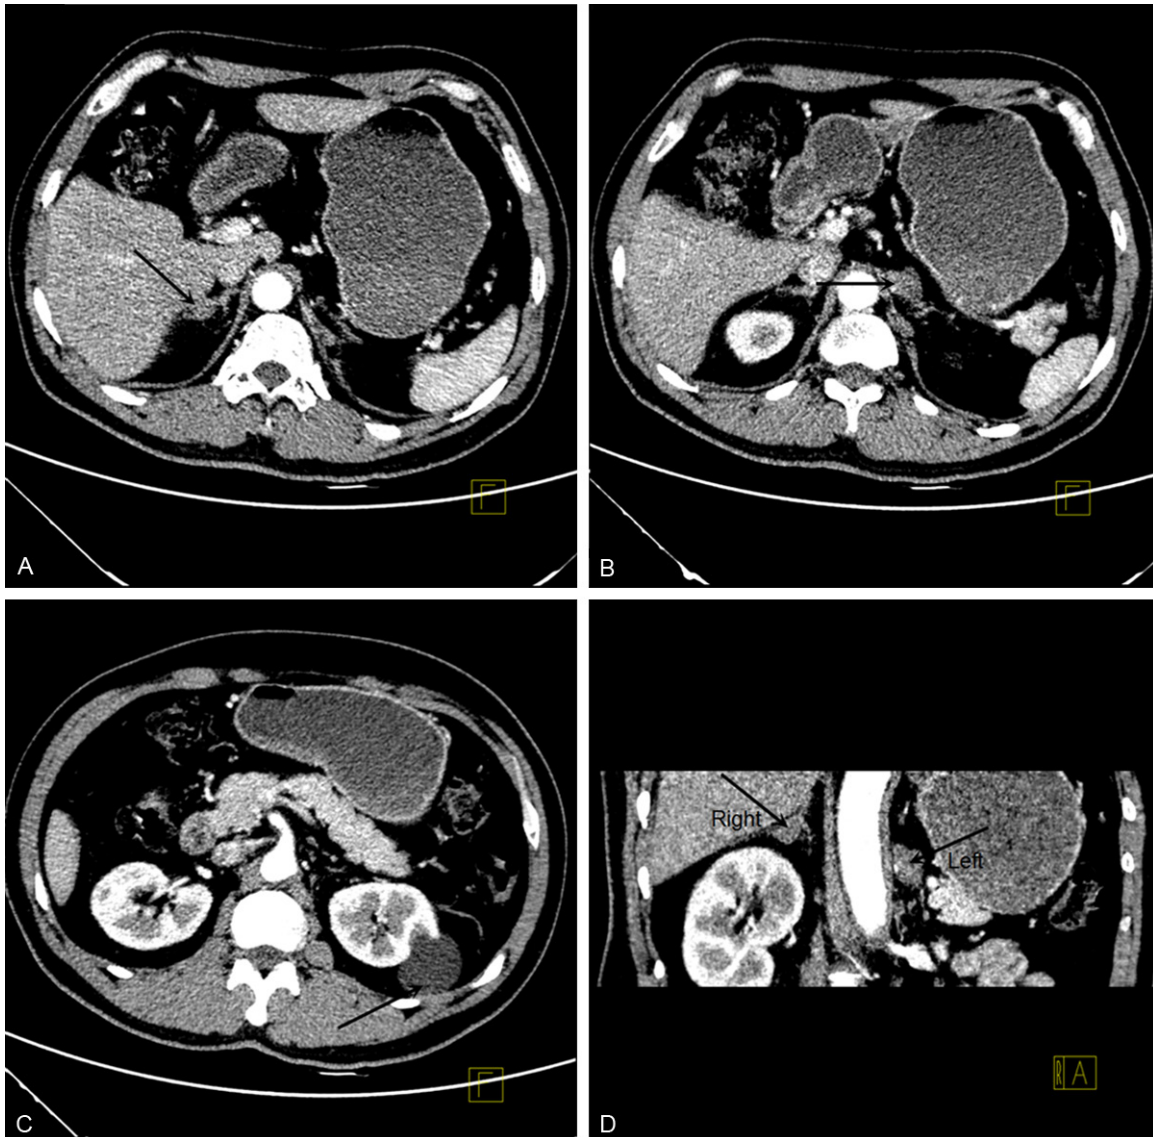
CT scan showing a right adrenal mass, about 1.5×0.9 in diameters (black arrow point to mass) (Panel A, Axial view). CT scan showing a left adrenal mass, about 1.7×2.1 cm in diameters (black arrow point to mass) (Panel B, Axial view). CT scan showing a left, rounded renal cyst, about 4.5 cm in diameters (black arrow point to renal cyst) (Panel C, Axial view). CT scan independently showing a left and right adrenal mass (black arrows point to the mass) (Panel D, Oblique coronal view).
